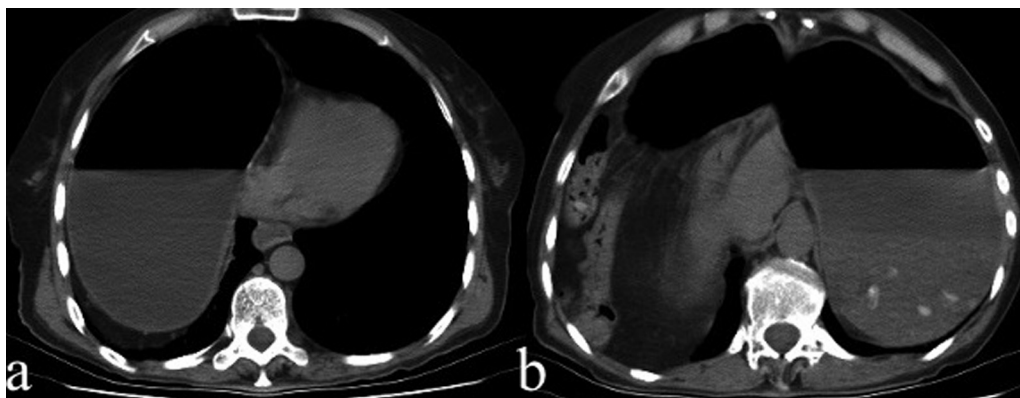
Abdominal CT; thoracic herniated part of the stomach (a) and remaining part of the stomach in the abdomen (b).
